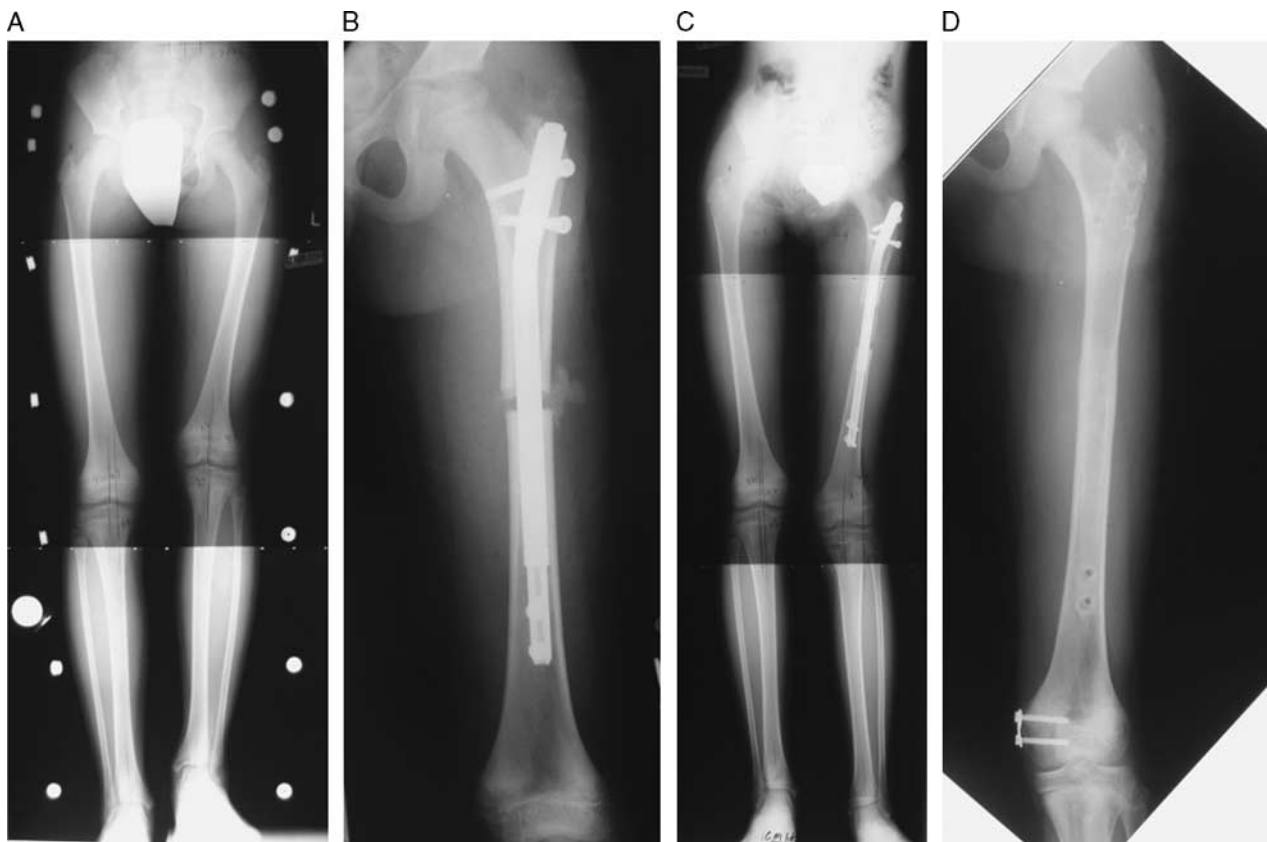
A-D, Eleven-year-old boy with left-sided congenital femoral deficiency. A, Preoperative limb length discrepancy of 3.7 cm. B, Immediate postoperative radiograph shows an ISKD inserted in the left femur through the greater trochanter. Notice the natural bone graft at the osteotomy site supplied from the reamed canal after venting. C, Lengthening completed 2 months after surgery. D, Regenerate healing and nail removal 15 months after initial surgery. The length achieved was 4.1 cm. An 8-plate was inserted on the medial distal femur to gradually correct valgus deformity. Reprinted with permission from Sinai Hospital of Baltimore. Copyright 2015, Rubin Institute for Advanced Orthopedics, Sinai Hospital of Baltimore, Baltimore, MD. All permission requests for this image should be made to the copyright holder.
